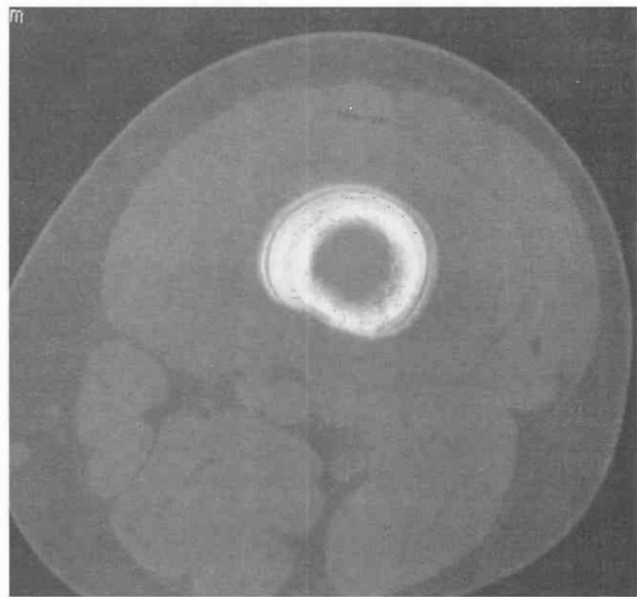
Ewing's sarcoma of the distal femur in a 15-year-old boy. The CT image at the bone window shows characteristic "onion skin" periosteal new bone formation.
